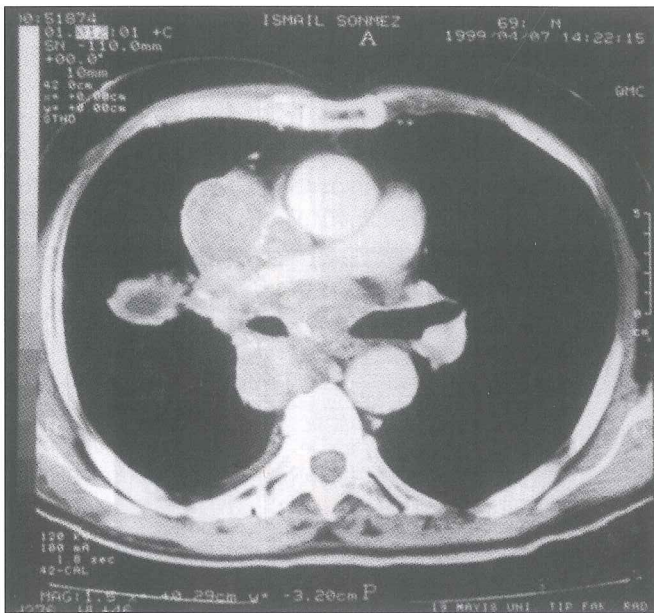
Thoracic CT scan at two cm caudal to the tracheal carina demonstrated a bulky right hilar mass encasing the right pulmonary artery and the superior vena cava
